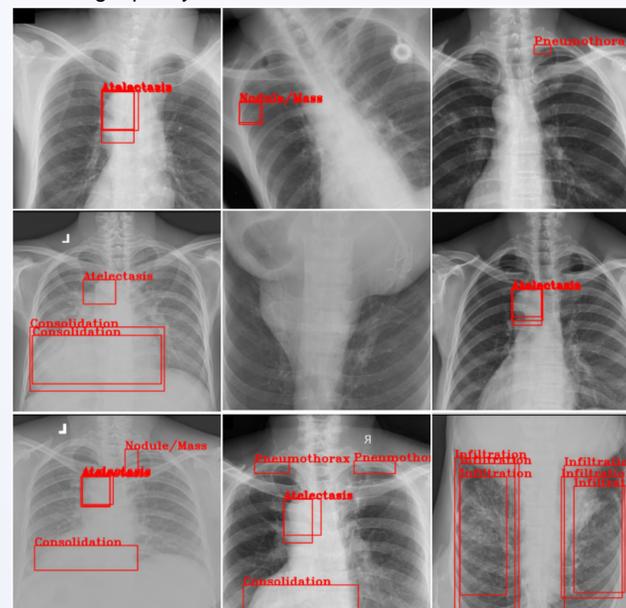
some examples of X-ray images classified and localized by the model and the image in the middle indicates no findings found (normal)
